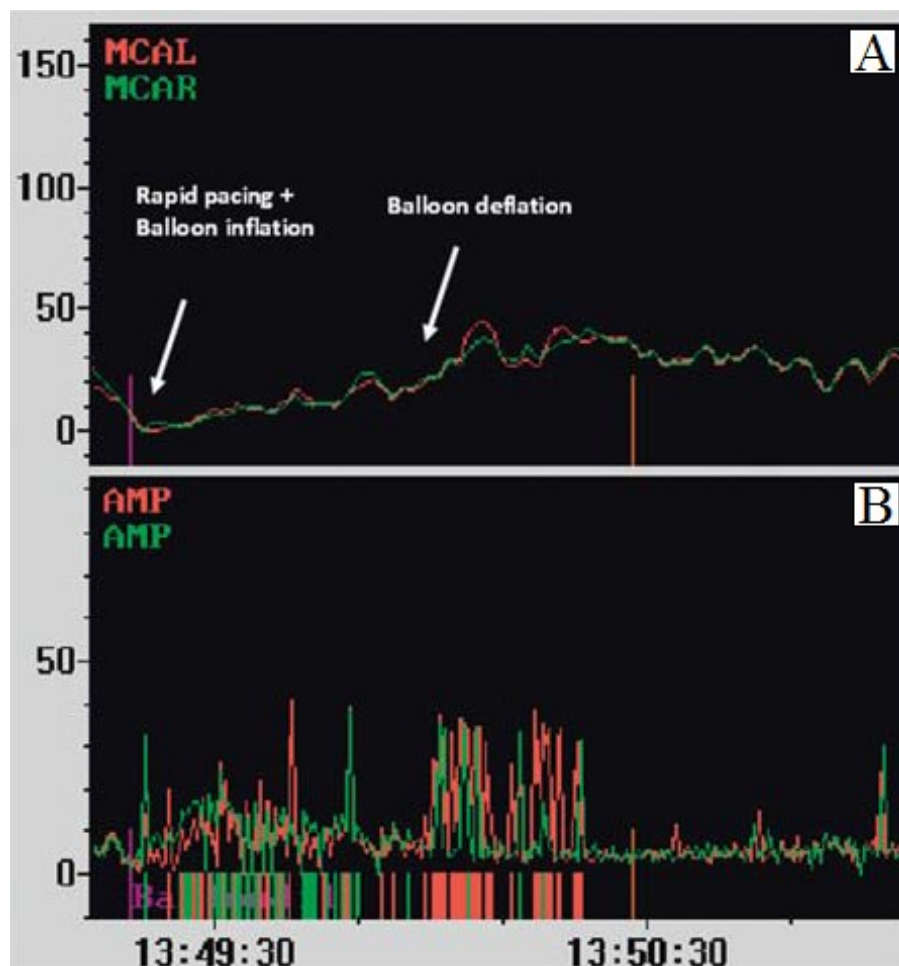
Doppler ultrasound examination of aortic balloon valvuloplasty. Flow velocities within the left and right middle carotid arteries (A) and flow acceleration within the left and right middle carotid arteries (B) that correspond to debris within the blood (Drews et al. 2011).
